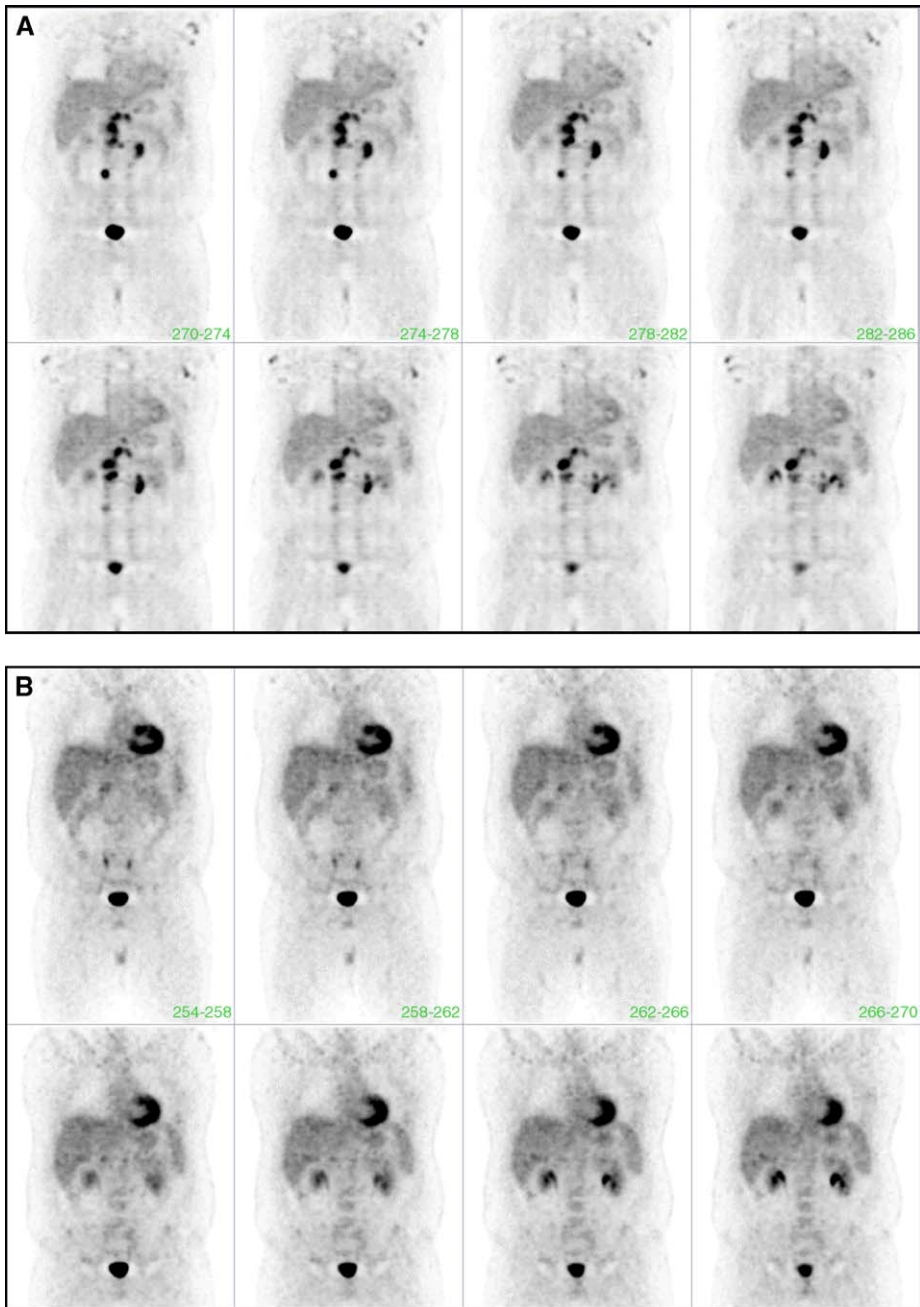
(A) Serial FDG-PET scans showing treatment response during and after the completion of chemotherapy. Coronal views of FDG-PET study show multiple focal areas of intense FDG uptake in the abdominal lymph nodes suggestive of metastatic involvement. (B) Follow-up FDG-PET study obtained 6 weeks after completion of chemotherapy shows no FDG uptake suggestive of good response to chemotherapy.
